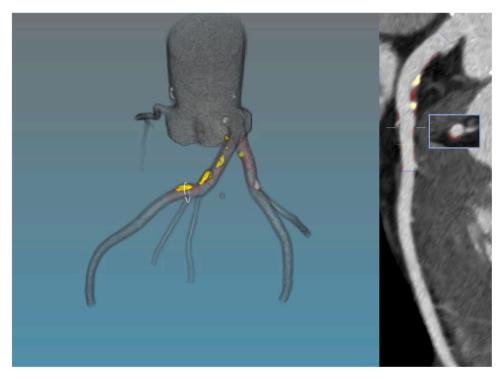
The quantitative plaque analysis from cardiac computed tomography angiography of a 60-year-old African American male with a history of smoking shows atherosclerotic plaque in left anterior descending artery with non-calcified (red) and calcified (yellow)components. 3D Rendering of the coronary tree on the left, curved multiplanar reformatted image of the left anterior descending artery on the right.
